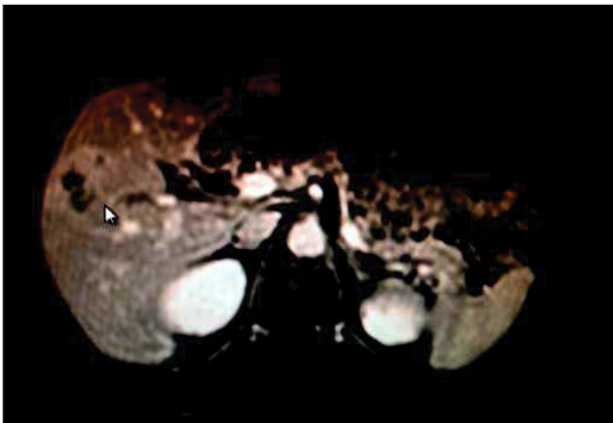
First patient, HCC appearance in MRI
